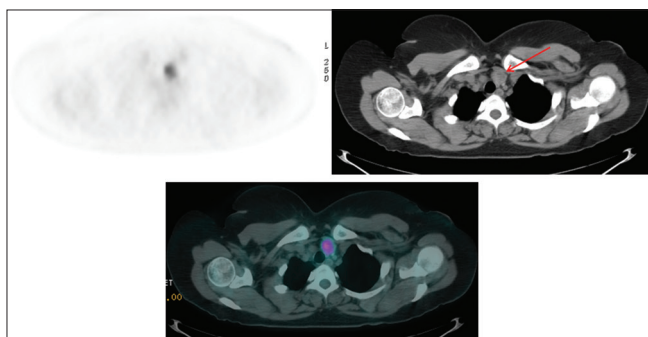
Axial positron emission tomography, computed tomography, and fused positron emission tomography/computed tomography is showing focal hypermetabolic thyroid nodule involving the left lobe (red arrow) in a newly diagnosed left breast carcinoma patient, and fine-needle aspiration guided by ultrasound revealing papillary thyroid carcinoma
